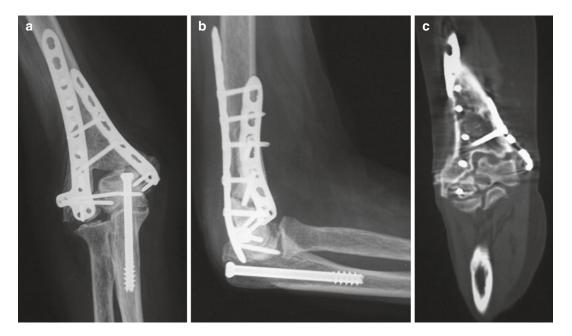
Distal humerus nonunion following a distal humerus fracture treated with perpendicular plates in a 79-yearold woman. (a) Anteroposterior view, (b) lateral view, (c) CT scan coronal view
